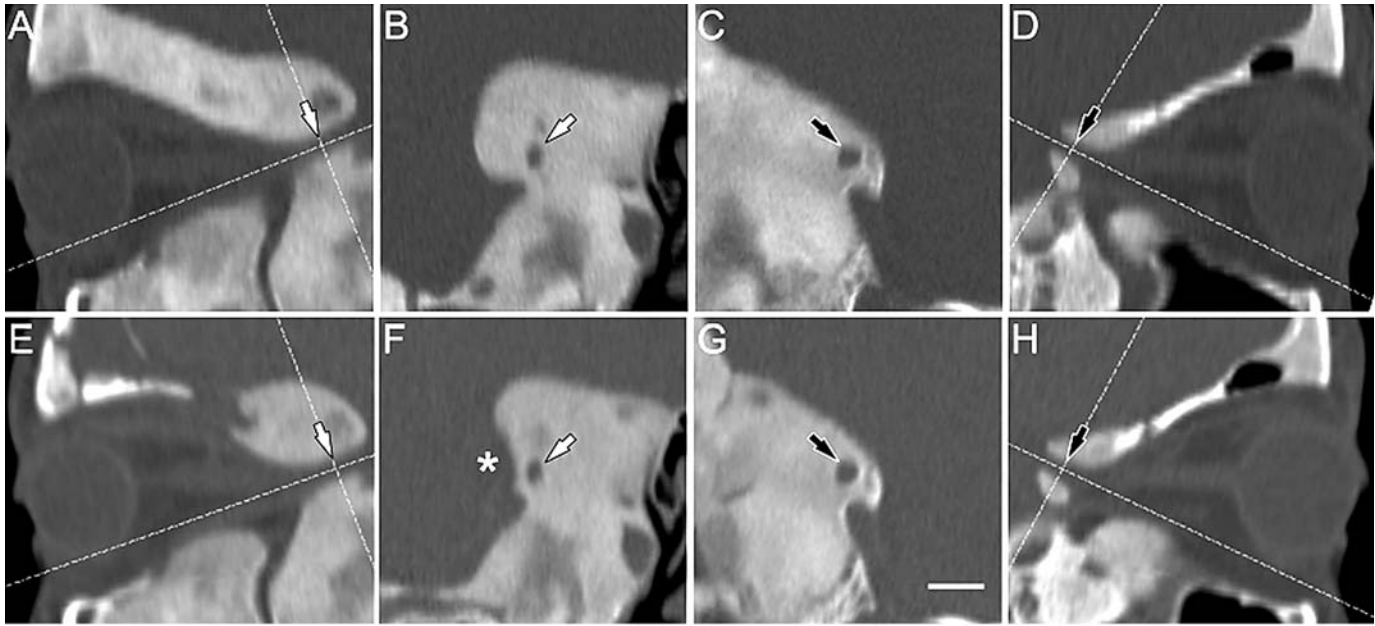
Preoperative (A–D) and postoperative (E–H) CT scans obtained from a 12-year-old girl with MAS and GH excess (Patient 7, Table 4) who underwent optic nerve decompression for a mild visual field defect. A–D, preoperative images demonstrating full encasement of both nerves, with marked narrowing of the right optic canal (A and B, white arrows) as compared to the left (C and D, black arrows). E and F, postoperative images obtained 1.5 years after surgery demonstrating that some
